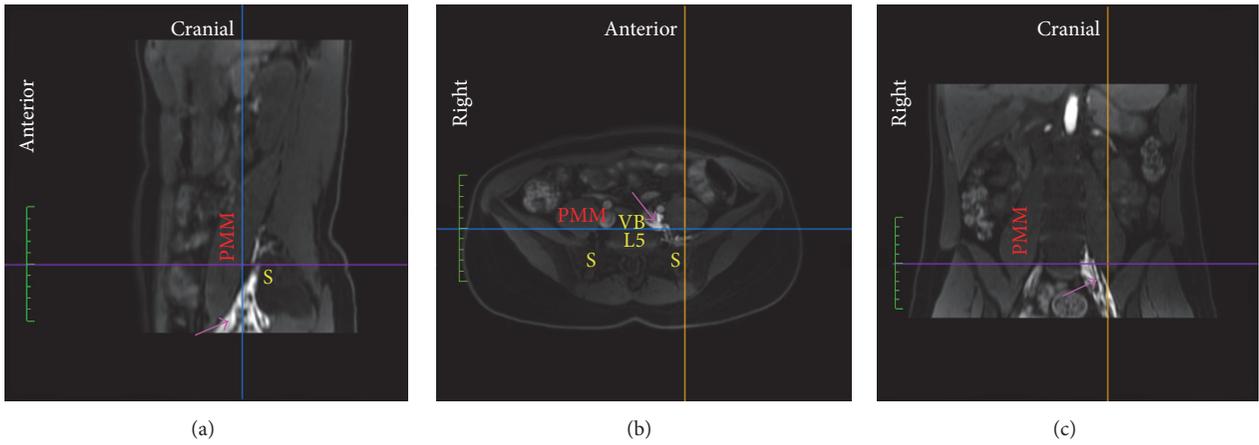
MRI of one subject visualizing spread of lidocaine-epinephrine added diluted contrast (magenta arrow) primarily medial to the psoas major muscle (PMM), that is, in the *parapsoas compartment*. (a) Sagittal plane. (b) Axial plane. (c) Coronal plane. Line (blue), position of coronal plane; Line (orange), position of sagittal plane; Line (purple), position of axial plane; S, sacral ala; VB L5, fifth lumbar vertebral body.
